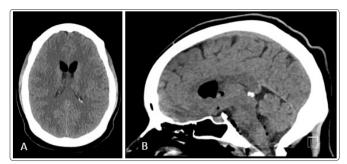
A and B showing transverse and sagittal head CT with moderate volume gas in the basal cisterns, frontal horns, and 3^{rd} and 4th ventricles and partial imaging of extradural gas in the upper cervical spinal canal.
